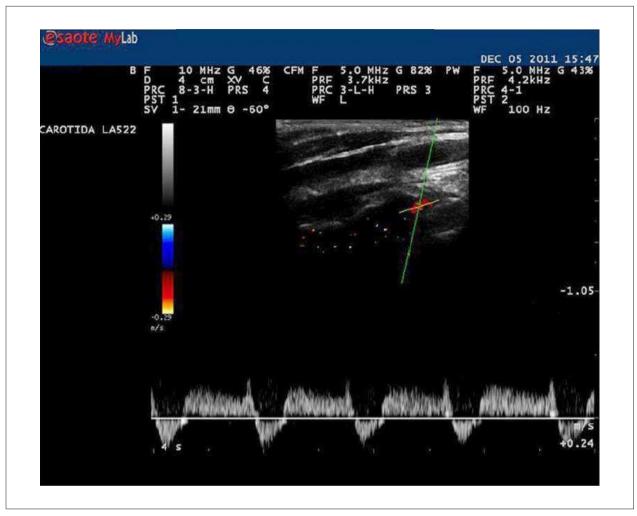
Spectral Doppler (PW) imaging of the right vertebral artery shows partially reversed flow, consistent with type 2 steal (intermittent or partial)¹⁵
